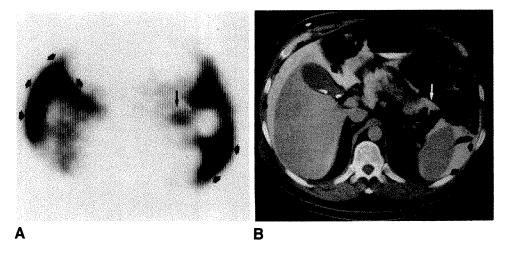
Visualization of complex upper abdominal fluid distribution on SPECT and CT.
